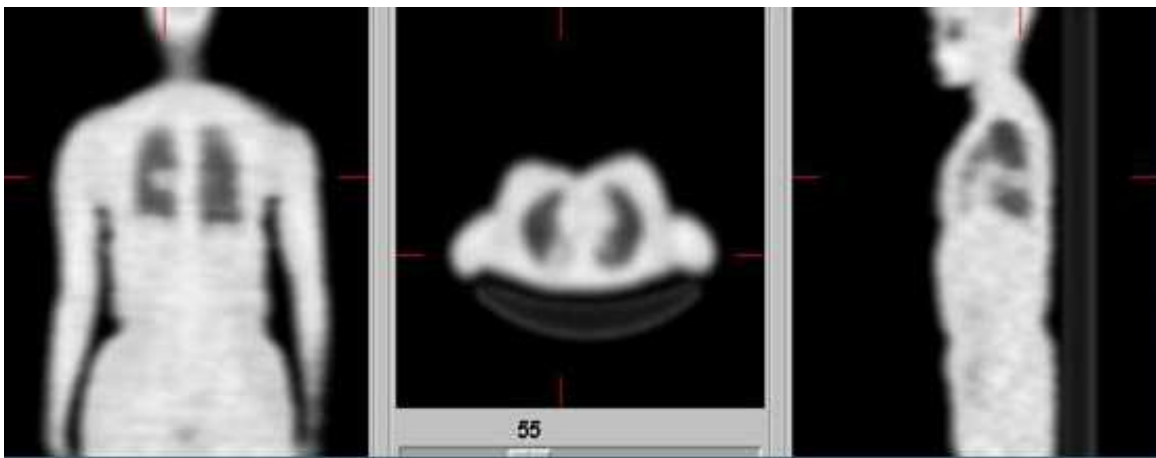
PET rod transmission source scan: Contemporary PET scanners no longer make use of rod-based transmission because CT has become the sole source of transmission-based attenuation correction.
